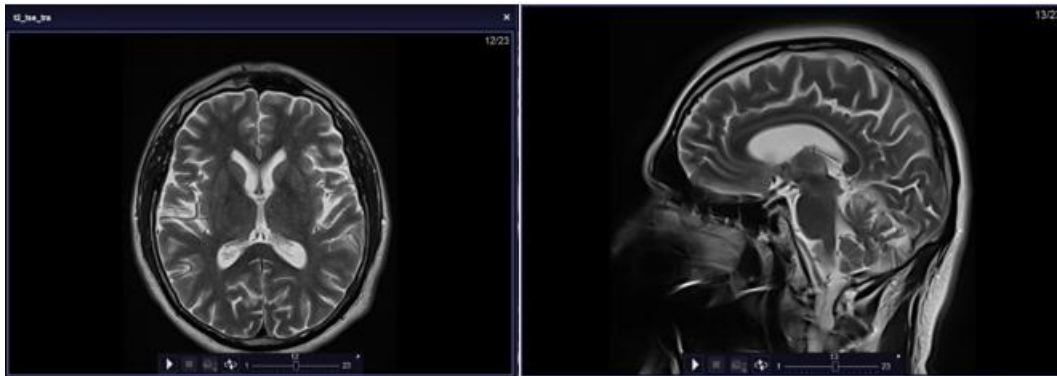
Magnetic Resonance Imaging (MRI) of our patient
